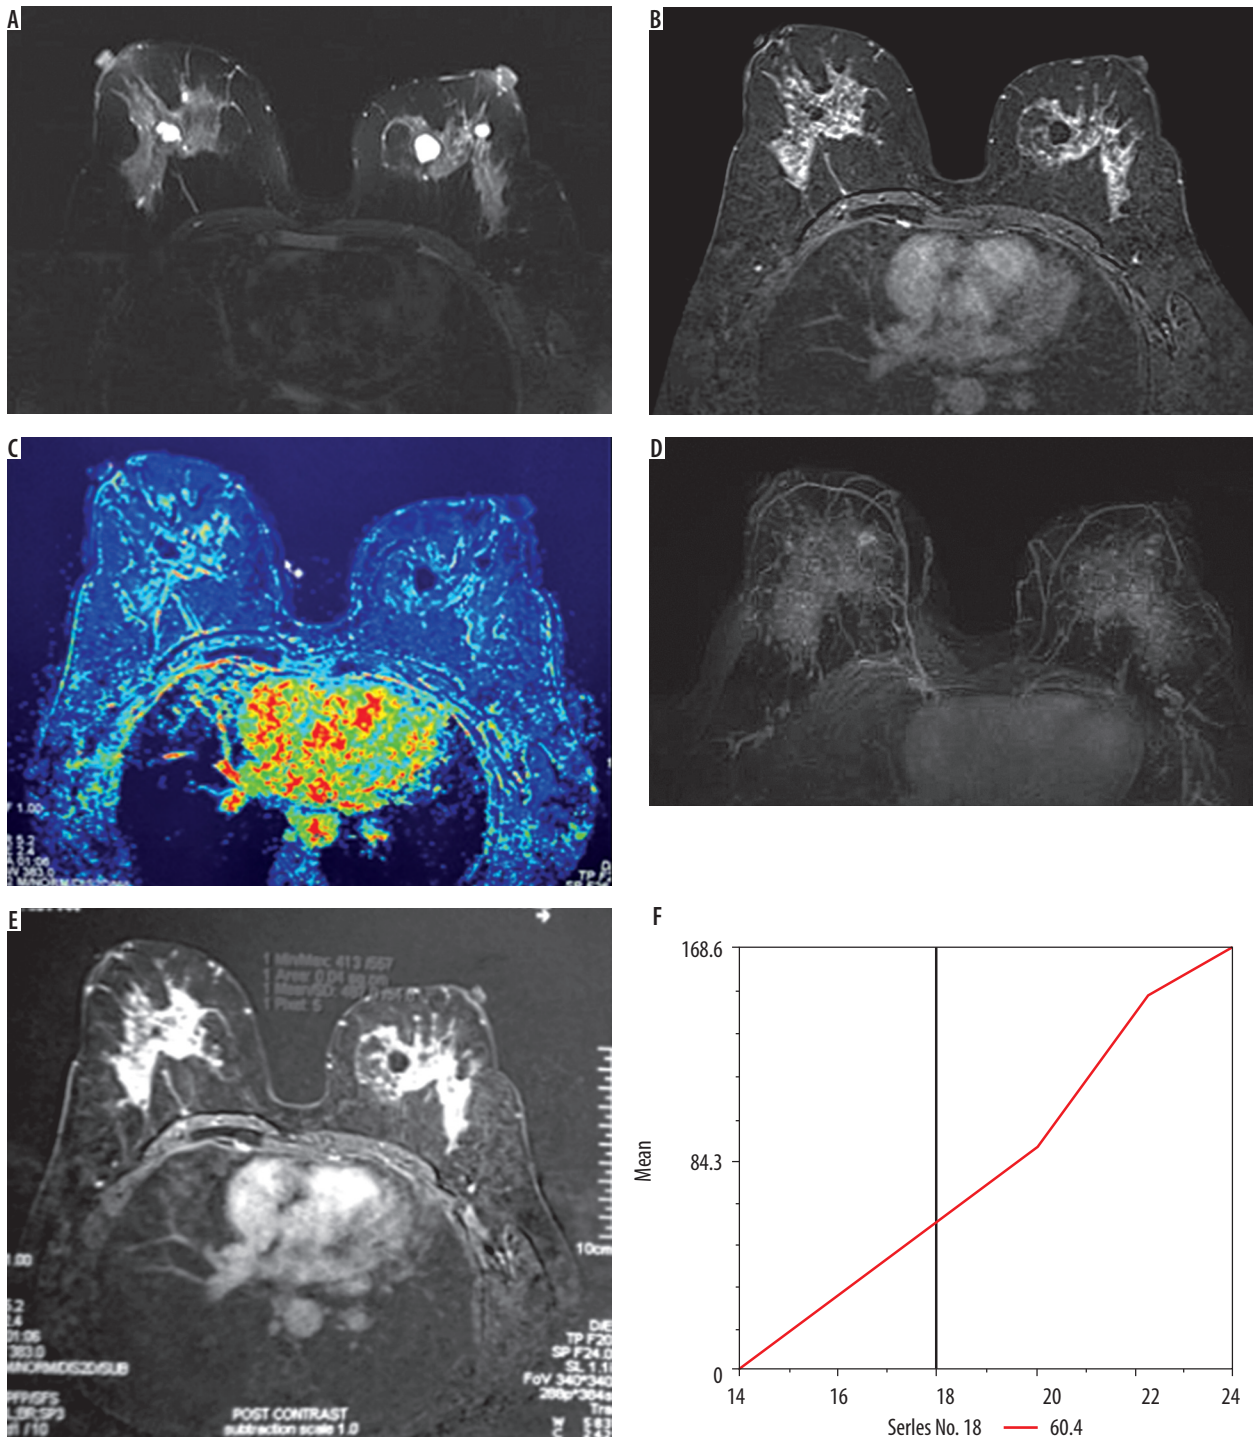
Magnetic resonance imaging breast in a case of multiple cysts in a 45-year-old woman. A) Axial STIR image showing two well defined hyperintense cystic lesions in the left breast and one cystic lesion in the right breast. B) Axial post contrast fat sat T1WI showing no contrast enhancement in the cystic lesions. C) Wash-in colour map and maximum intensity projection image showing the smooth margin oval cystic lesions and no post-contrast enhancement. D) Maximum intensity projection image show no post contrast enhancement. E-F) Time signal intensity curve of the cystic lesions showed type I kinetic curve (persistent enhancement in the delayed phase)
